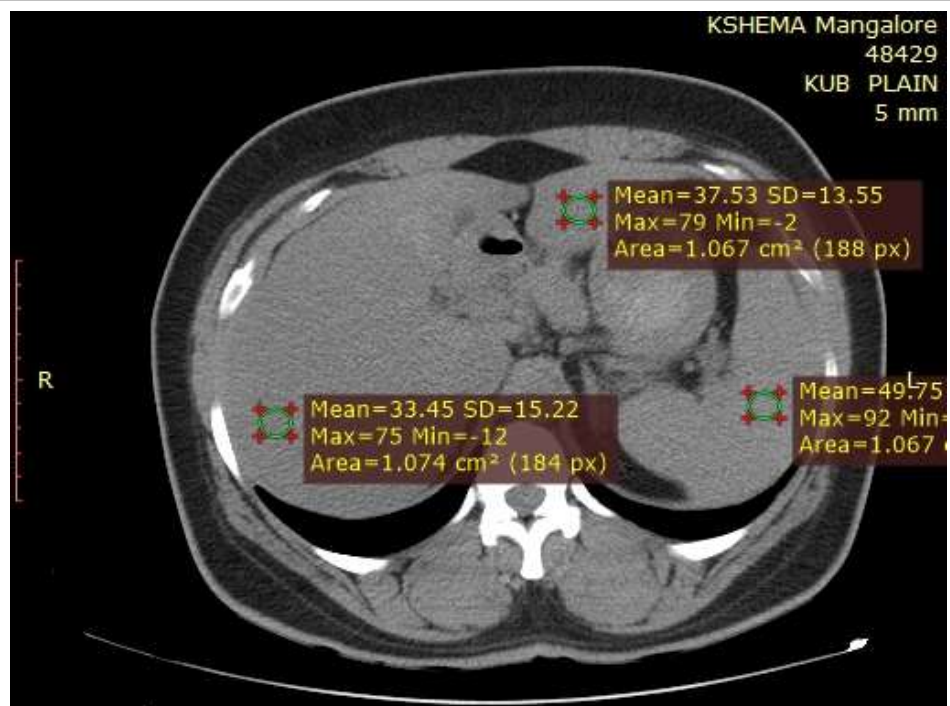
Unenhanced CT scan shows fatty liver with an attenuation value of right and left lobe of liver 33HU and 37HU respectively and attenuation of spleen as 49HU indicating grade I fatty liver
